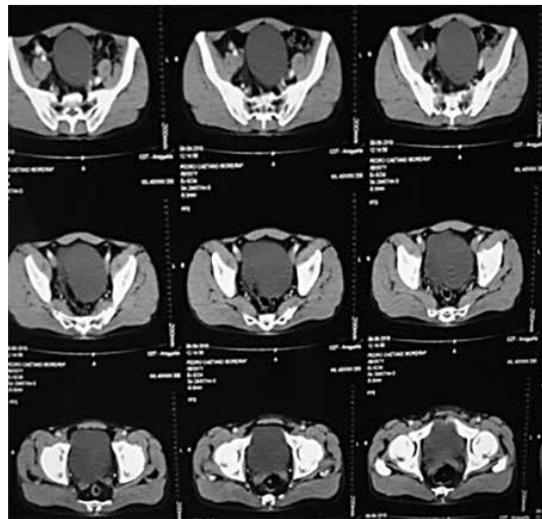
Abdomen computed tomography with contrast that revealed hyper-dense nodulation with a cystic aspect, non-contrast capturing, measuring 9.0 x 7.1 cm in its greatest transverse axes, located in the hypogastrium, without adherence to the bladder.
